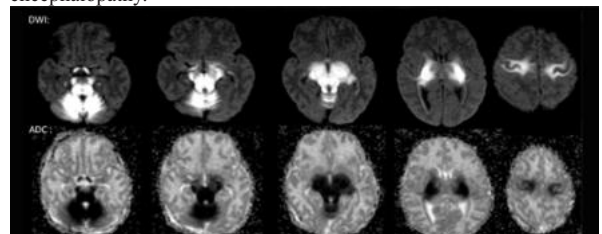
Diffusion-weighted imaging (DWI) and ADC maps showing restricted diffusion in basal ganglia, thalami, and corticospinal tracts—hallmark findings in acute MSUD encephalopathy.
